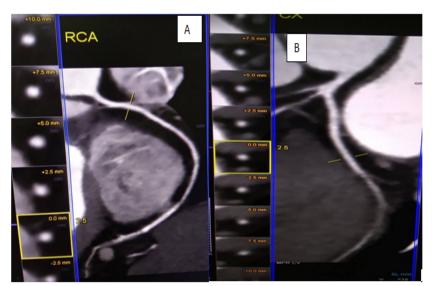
(Cardiac CT angiography): A & B show no apparent pathology in right coronary artery
